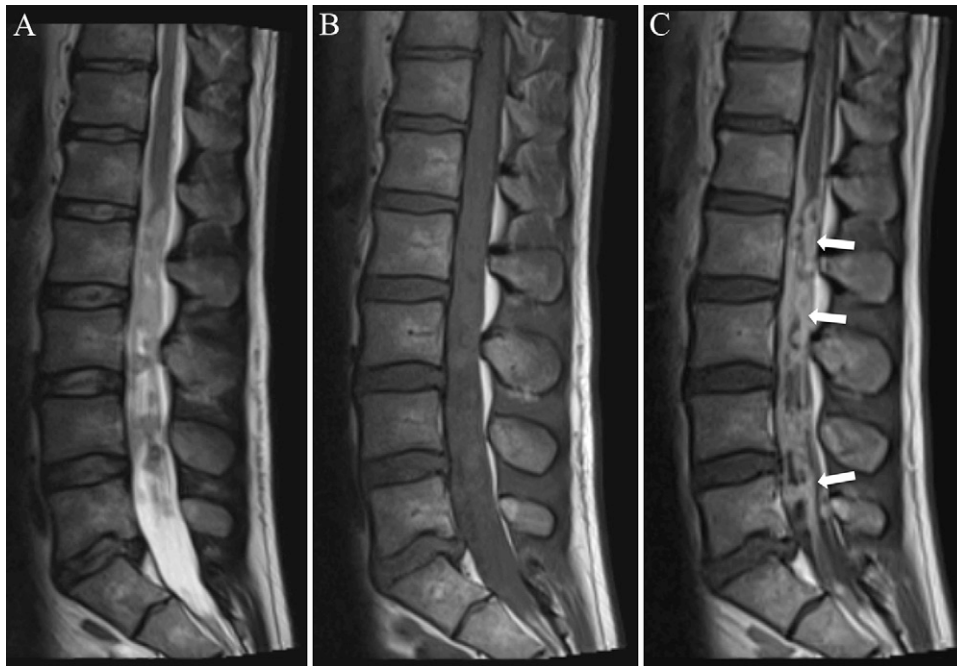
Sagittal slices from MRI of the lumbar spine, with sequences of T2 (A), T1 without contrast (B), and T1 with contrast (C). There is a contrast-enhancing soft tissue epidural mass filling the thecal sac and compressing the adjacent conus medullaris (arrows) and, below that, the nerve roots of the cauda equina.
